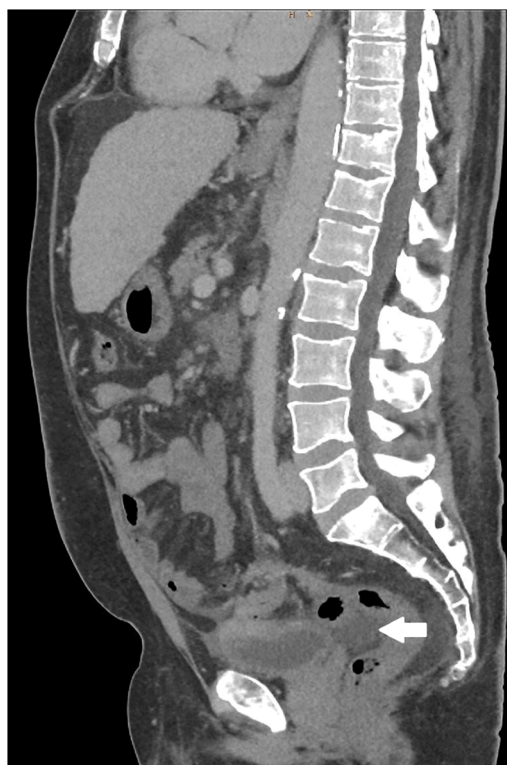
The sagittal section of abdominopelvic CT scan showing hydro-aerial collection located between sigma and bladder (white arrow).
